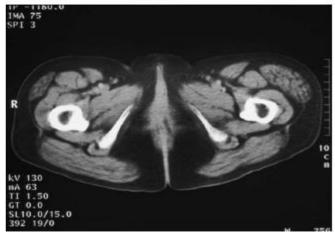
Fifty-seven-year-old female with history of melanoma and long term anticoagulation, presented with a 5-week history of enlarging left anterior thigh mass. Axial CT scan through the lower pelvis revealed unilateral enlargement of the left TFL muscle
